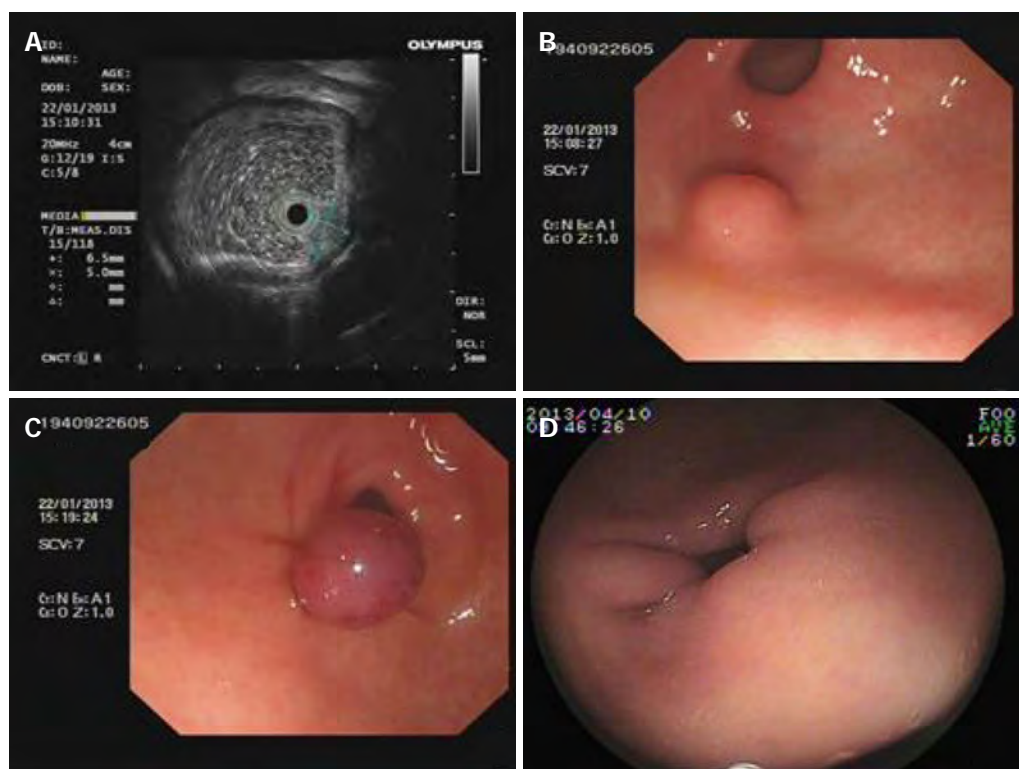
Imaging in case 2. A: Endoscopic ultrasonography image of the submucosal lesion; B: Endoscopic view of the lesion in gastric antrum; C: Endoscopic view showing the ligated lesion; D: Endoscopic image at 11 wk after ligation, showing healing at the ligation site.
